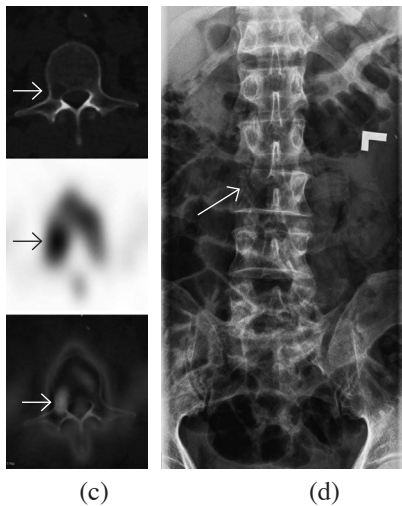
(c) Additional bony lesions on Evolution SPECT were seen as osteophyte at C3 vertebra (not shown) and an osteolytic destruction of right pedicle and right lateral aspect of L3 vertebra (arrow) on SPECT/CT imaging. (d) An osteolytic lesion at L3 vertebra was clearly observed on plain radiograph in 3 months later.
